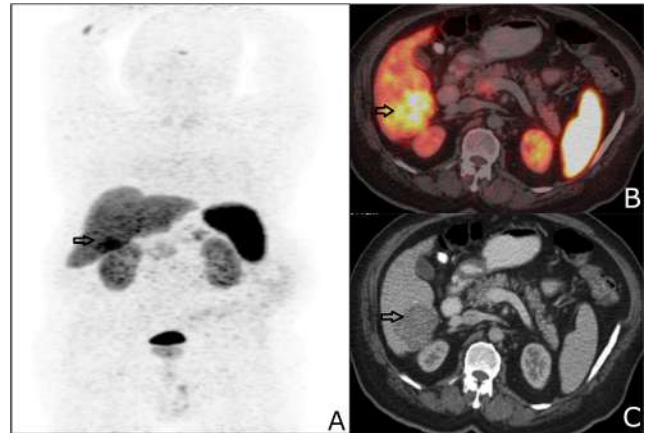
A): Maximum intensity projection (MIP) images show focal tracer uptake in the liver; B) and C): Transaxial fused 68Ga DOTANOC PET/CT and corresponding axial CT images respectively showing somatostatin receptor-expressing lesion in segment VI of the liver
